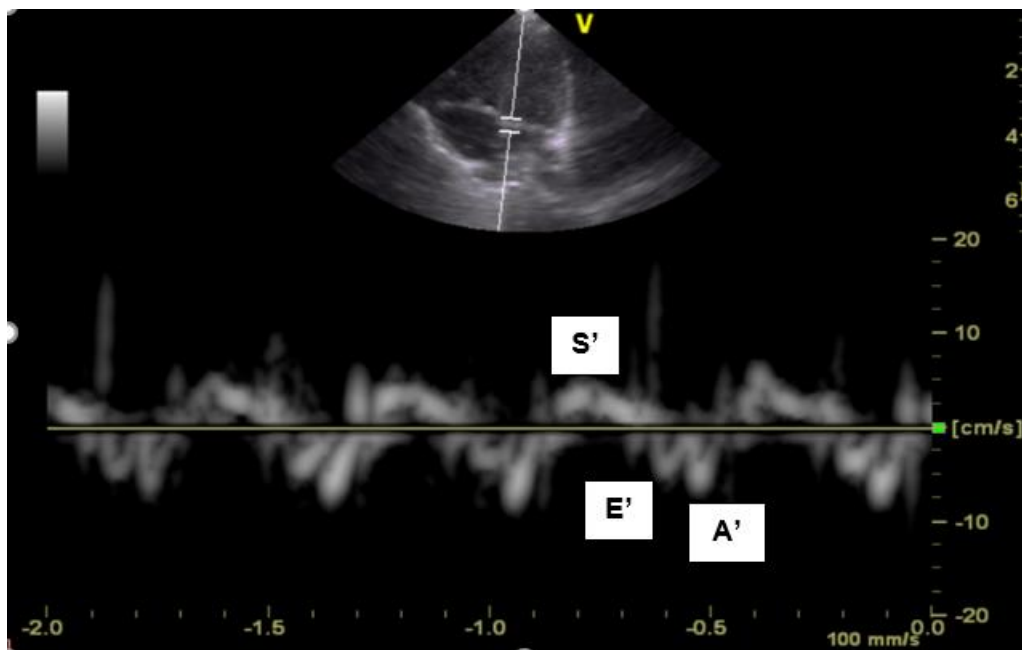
5 Septal mitral annular tissue Doppler (Image taken by main author at CHBAH 2017).
